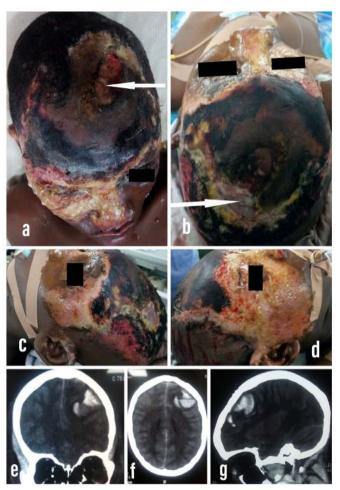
Showing areas of denuded scalp and cranial computed tomography scan images. Charred fronto- parietal scalp images are shown in 'a-d', with partial thickness burns on the superior face. White arrows in 'a' and 'by show exposed calvarium. Intracerebral haematoma (areas of complex pattern of hypodensities in the left fronto-parietal cerebrum) is shown in 'e', 'f' and 'g', representing the coronal, axial and sagittal slices respectively. 975x1411mm (72 x 72 DPI)
